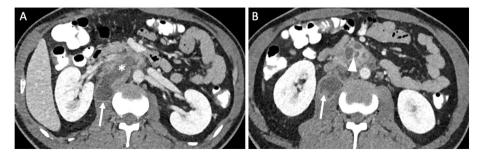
Tuberculous abscess. Contrast-enhanced CT demonstrates a peripherally enhancing collection in the enlarged right psoas muscle (arrow) which appears connected (asterisk) to adjacent multiple necrotic lymph nodes (arrowhead).
